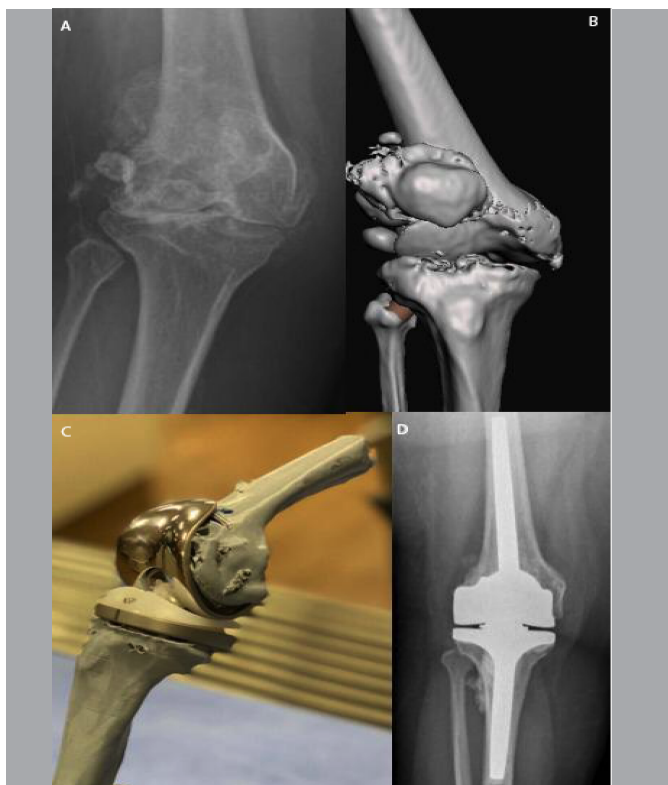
Example of using 3D printing for surgical planning in a patient of very short stature (1.38m). A) Anteroposterior knee radiography showing advanced osteoarthritis of the knee; B) 3D model developed from computed tomography; C) Biomodel printed from the model of Figure 2B, in which a total knee arthroplasty was performed; D) Post-operative radiography demonstrating a result similar to the biomodel.
